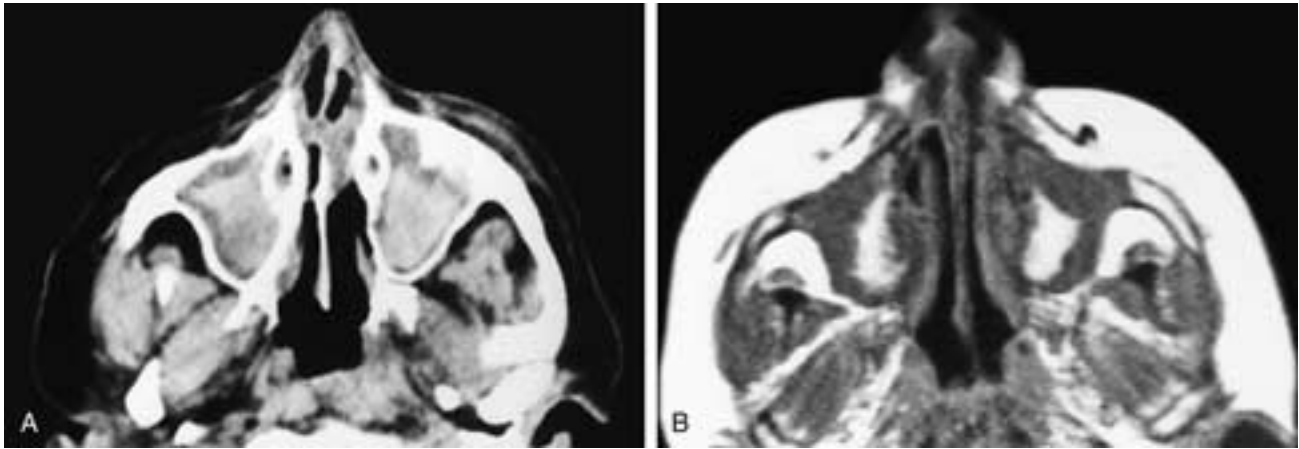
In A, an axial CT scan shows central areas of increased attenuation in both maxillary sinuses, separated from the sinus walls by a thin zone of mucoid attenuation. This picture is consistent with either chronic sinusitis with desiccated sinus secretions, fungal sinusitis with a mycetoma, or sinus hemorrhage. In B, a T1-weighted MR image, the central area of each maxillary sinus has high signal intensity consistent with hemorrhage. The surrounding low signal intensity material is mucosa and fresh secretions.
